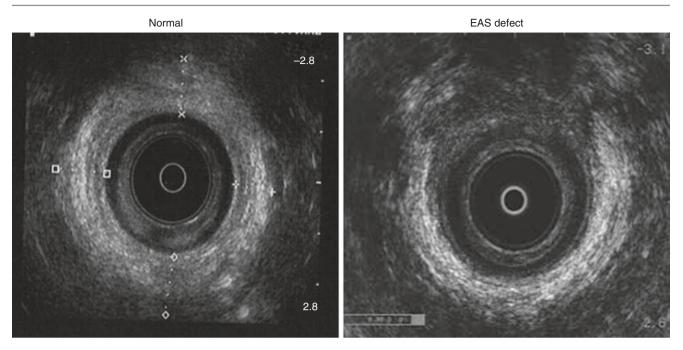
Endorectal ultrasound. (Courtesy of S. Menees, MD, used with permission)
